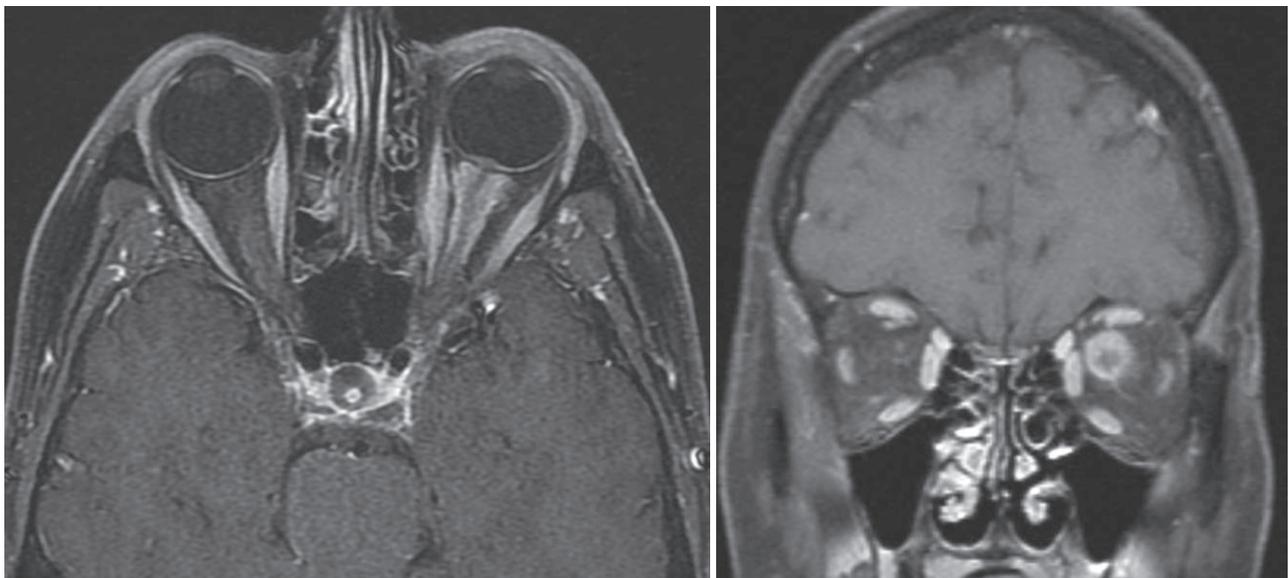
In this patient, an axial (left) and coronal (right), T1-weighted, contrast-enhanced MRI shows diffuse enlargement and enhancement along the length of the left intraorbital optic nerve sheath.
